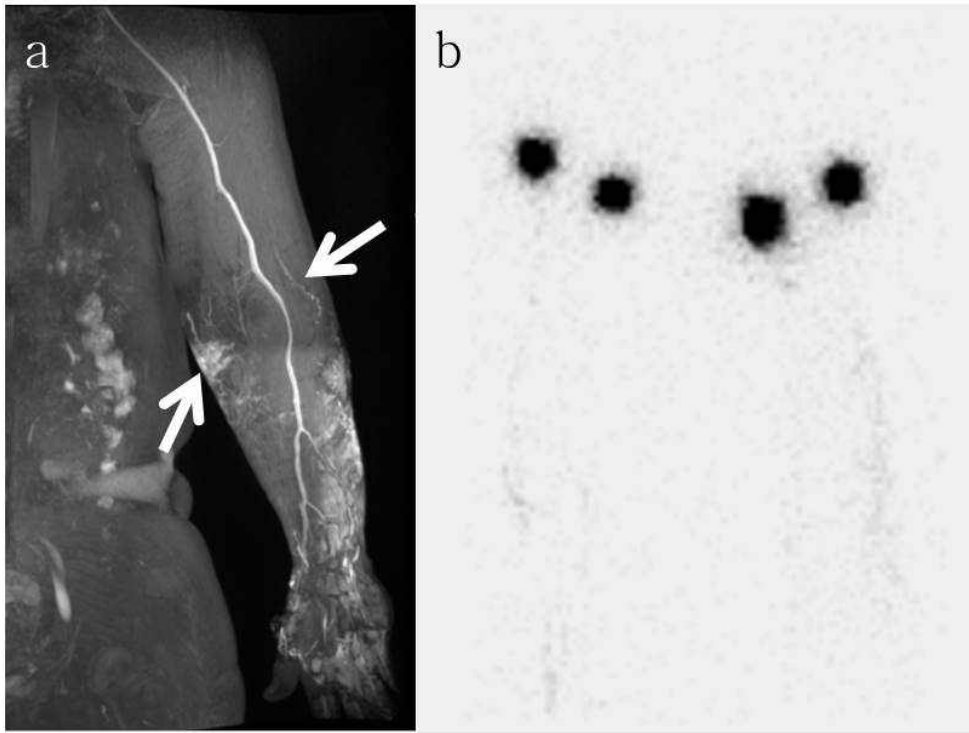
Comparison of depiction of lymph vessels by MR lymphangiography and lymphoscintigraphy in a 55-year-old female with stage II lymphedema. (a) MR lymphangiography clearly demonstrates beaded appearance of lymph vessels (white arrows) at the left elbow at both ulnar and radial side. (b) Lymphoscintigraphy revealed only faint dotted line at the corresponding area.
